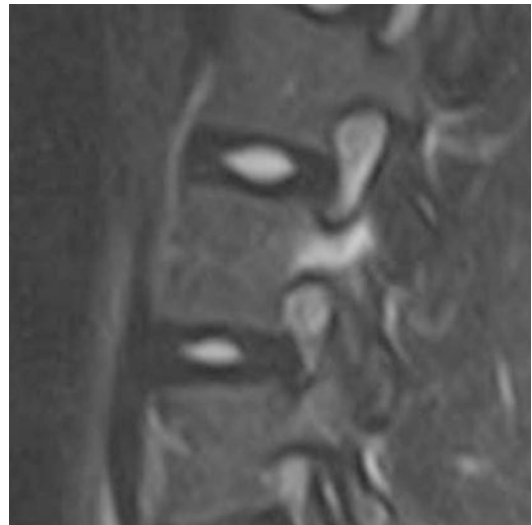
Sagittal MRI image shows well-limited stress reaction in the pars interarticularis
